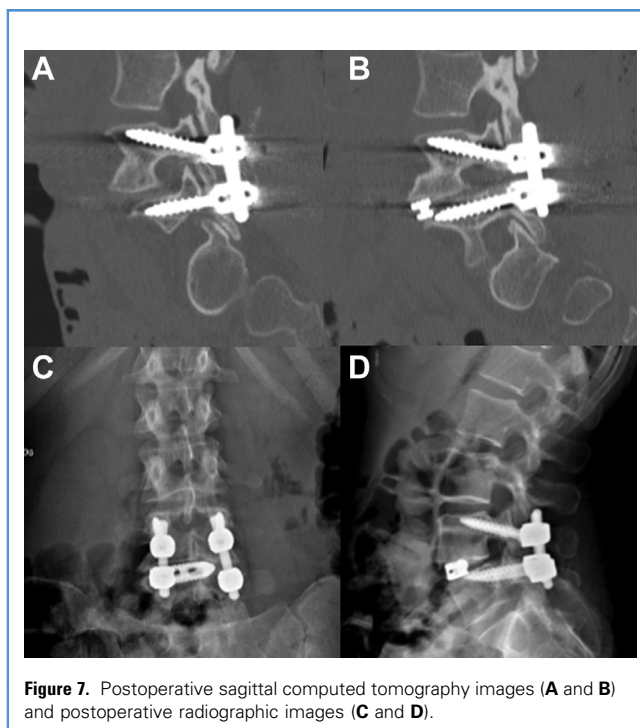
Postoperative sagittal computed tomography images (A and B) and postoperative radiographic images (C and D).
